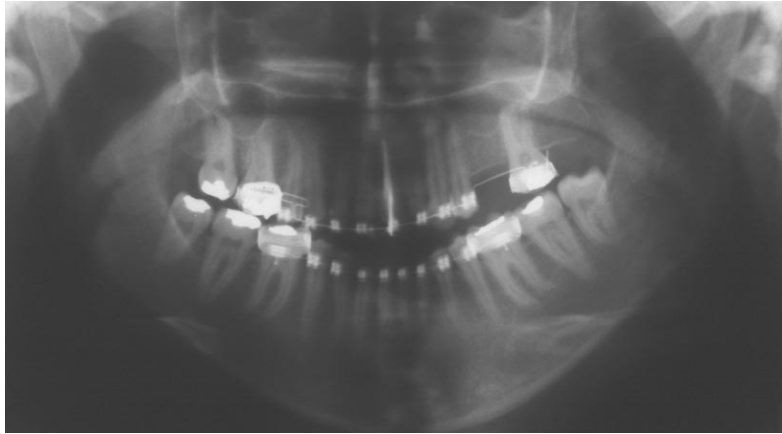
Panoramic radiograph before autotransplantation.
